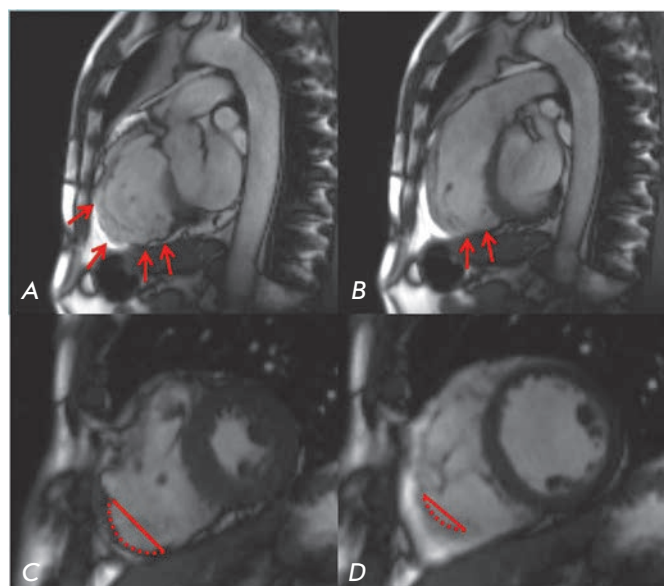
Cardiac MRI of a patient with ARVD (own data). Bright blood images in the right ventricular outflow tract (RVOT) plane obtained in end diastole (A) and end systole (B) show microaneurysms (arrows) in the right ventricle free wall with persistent bulge in both phases. Short-axis bright blood images obtained in end diastole (C) and end systole (D) demonstrate dyskinesia (bulge in systole, arrows) at the acute angle of the right ventricle
